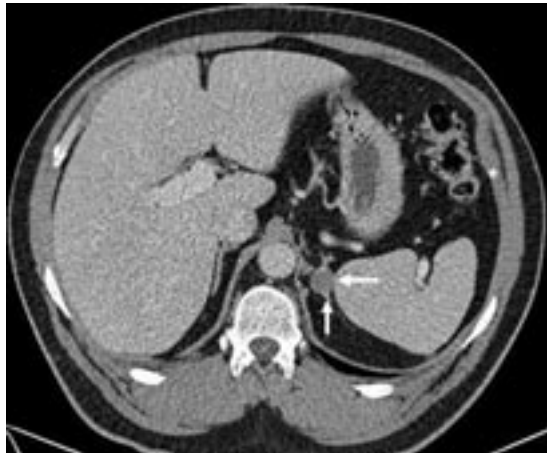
Noncontrast CT scan image of a left adrenal mass with attenuation of -10 Hounsfield units, consistent with a benign adenoma.
